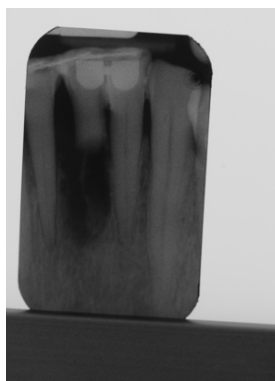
X-ray post root amputation.*
